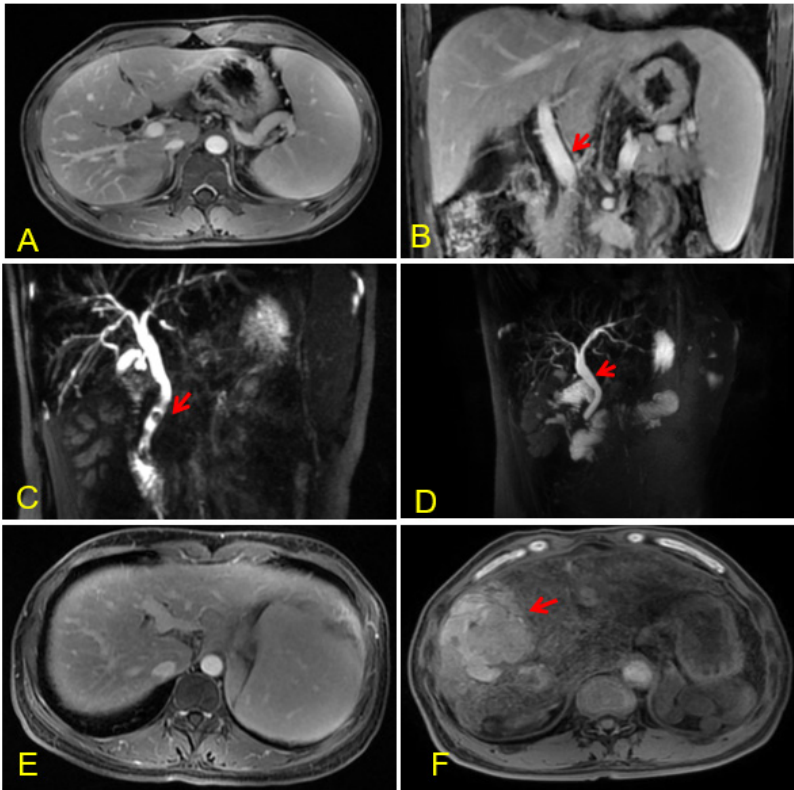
A-D (Patient 1), A: Abdominal ultrasound in August 2018 did not show any definite gallbladder stones. B: Abdominal MRI indicated mild dilation of intrahepatic bile ducts and common bile duct. C: MRCP in January 2019 showed multiple stones in the common bile duct. D: MRCP in August 2020 showed mild dilation of intrahepatic and extrahepatic bile ducts (one year and more after gallbladder removal). E: Patient 2 showed mild dilation of intrahepatic bile ducts (8 years after gallbladder removal). F: Patient 3 progressed to hepatocellular carcinoma (27 years after gallbladder removal).
